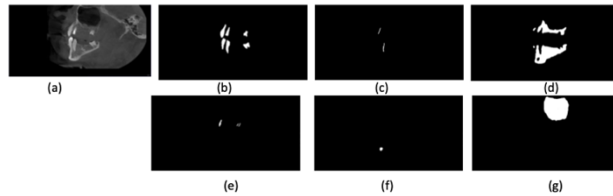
An example of tangential images and six segmentations: (a)panoramic radiograph,(b)teeth,(c)major nerve,(d)bone,(e)restoration,(f)root canal,(g)sinus
